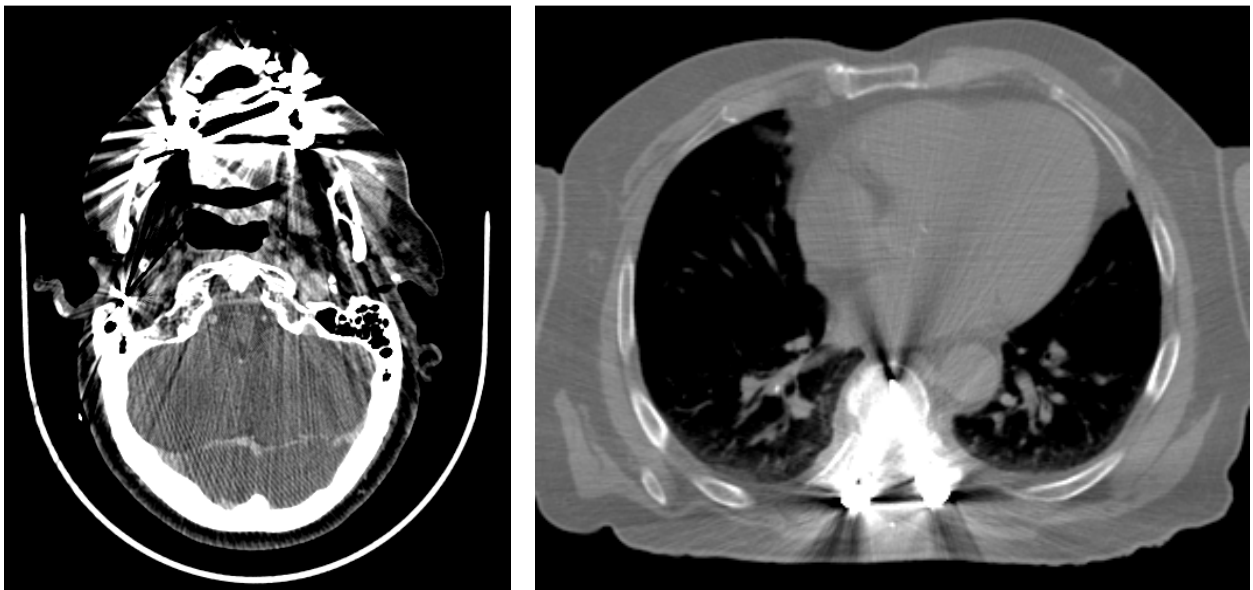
Axial CT images showing streak artifacts due to a) dental fillings and b) a spinal fixation device.
